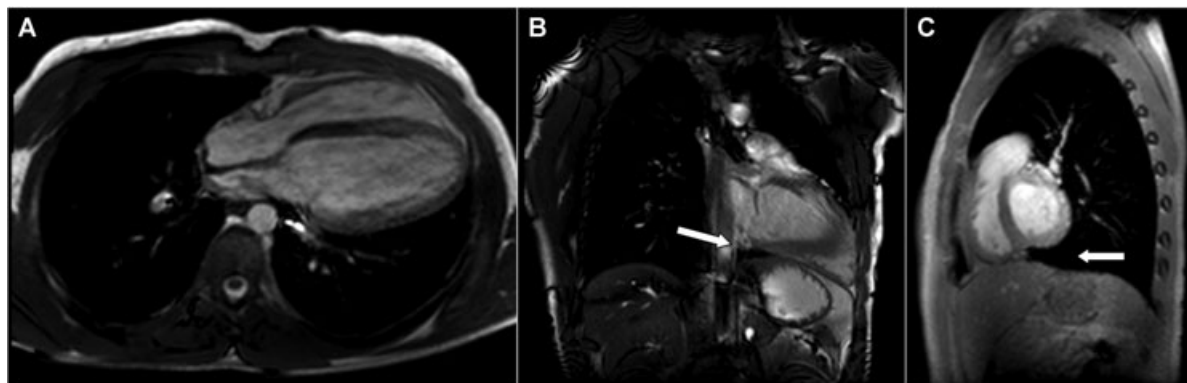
Magnetic resonance imaging: A. heart displaced into the left hemithorax and interposition of the lung between the heart and diaphragm (arrow) both in B. coronal and C. sagittal axis.
